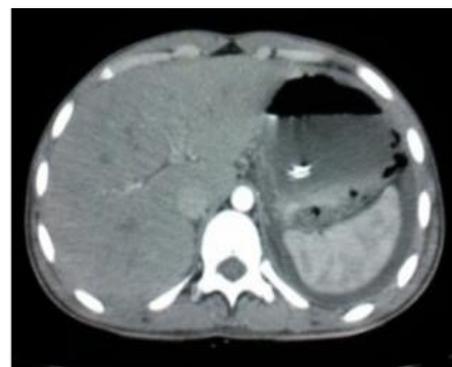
CT scan of the abdomen. Note the air in the wall of the stomach.
